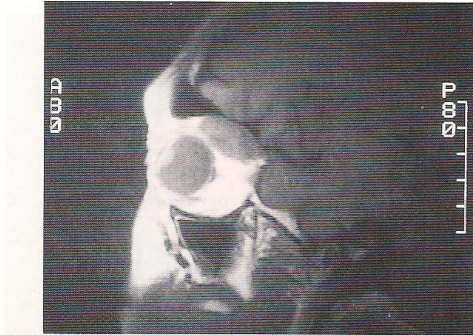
Sagittal magnetic resonance imaging in T1-weighted image showing ovoid shape of the superior orbital mass.
